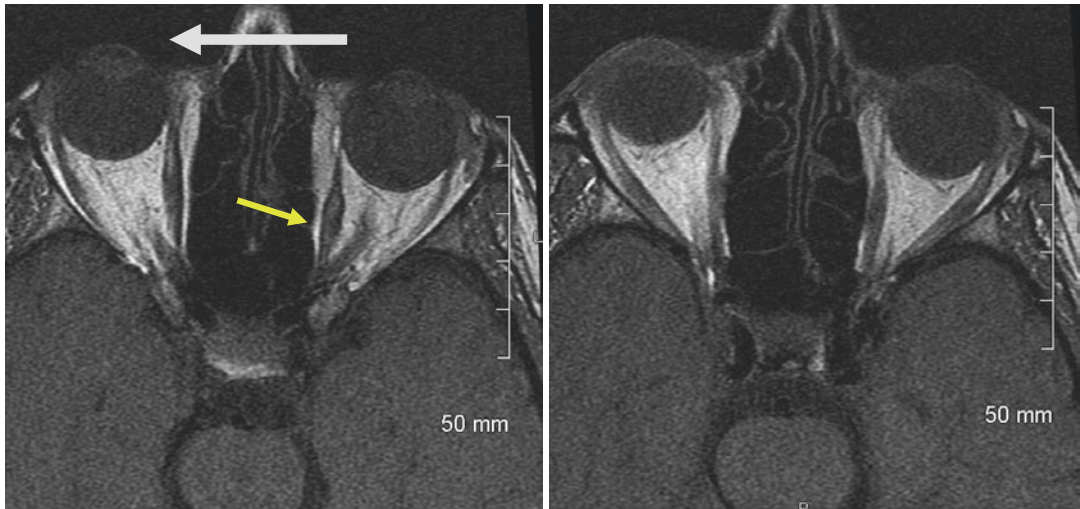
Dynamic MRI of a right medial rectus muscle (RMR) slipped in its capsule. In the image on the right, the patient is in right gaze. The RMR looks unremarkable. In the image on the left, the patient is attempting to look
